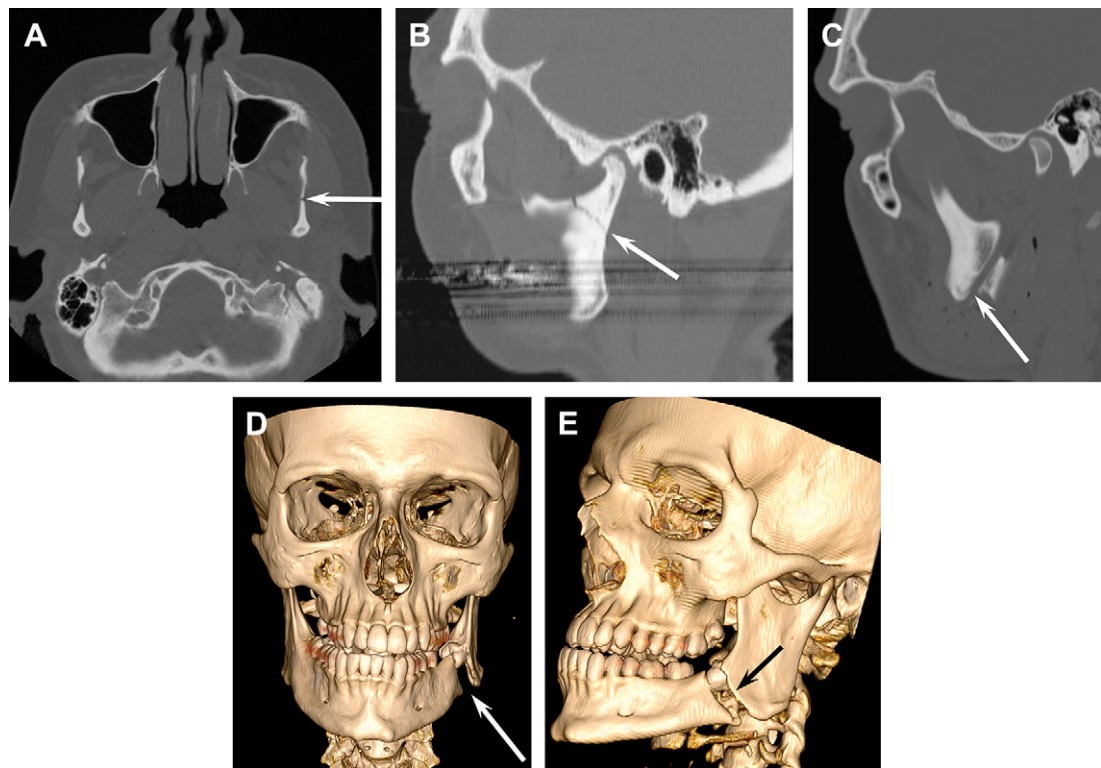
Utility of CT postprocessing in the evaluation of mandibular fractures. (A) Axial CT image through the mandibular ramus depicts a subtle fracture of the left sigmoid notch (arrow). The fracture might be easily overlooked in this plane. (B) The subcondylar fracture (arrow) is much more evident, and better characterized, on sagittal reformatted image. (C) Sagittal reformatted image in another patient demonstrates the relationship between the fracture and the inferior alveolar canal (arrow). (D) Surface-rendered 3D reconstruction in frontal projection provides surgeons with an excellent gestalt of the fracture pattern (arrow). (E) Surface renderings can be performed in any projection to best depict the fracture (arrow).
